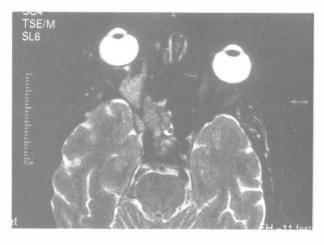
Brain and orbital MRI scan showing a mass arising from the pituitary gland and extending into the right orbital apex.
